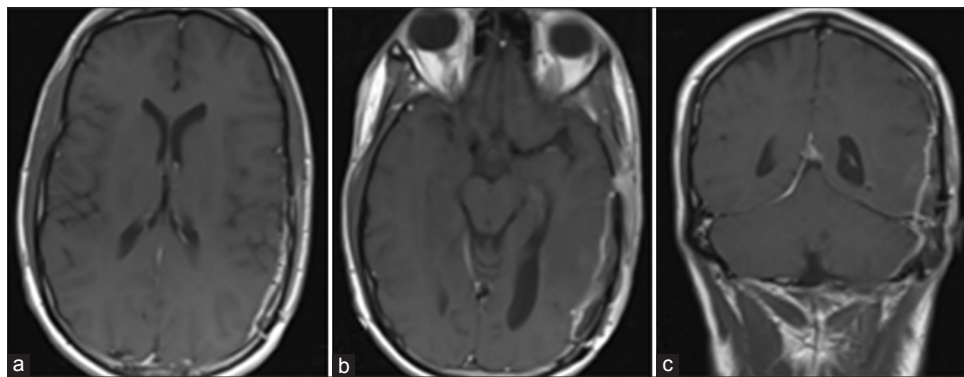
Axial (a and b) and coronal (c) post-gadolinium T1-weighted MRI studies performed 3 months after showing no recurrence after the second surgery and one cycle of radiotherapy
